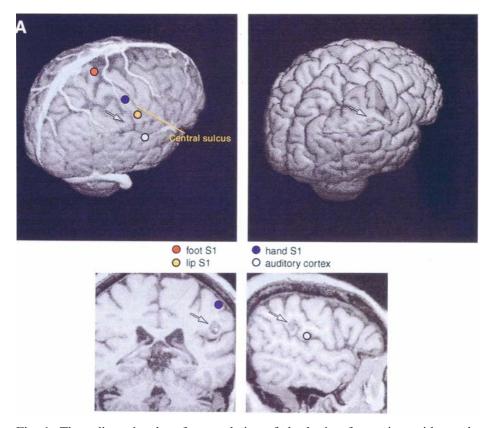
Three-dimensional surface rendering of the brain of a patient with a sub-cortical cavernous hemangioma in the right lower parietal lobe. Left, above: Cortical veins and sources of somatosensory MEG fields evoked by electrical stimulation of the median nerve (hand S1), the tibial nerve (foot S1) and lip (lip S1), along with the auditory evoked field (at a latency of 100 ms), are indicated by dots. Right, above: A section of the surface rendering was removed to reveal the subcortical cavernous hemangioma, and the sulcal route (arrow) used for its removal. Below: on the left a coronal MRI section showing the source of the median nerve evoked field (dot) and on the right a sagittal section showing the source of the auditory evoked field (dot); The arrows show the approximate location of the tumour, that is below the median nerve source and posterior to the auditory source. (Adapted with permission from (Mäkelä, Kirveskari *et al.* 2001))
